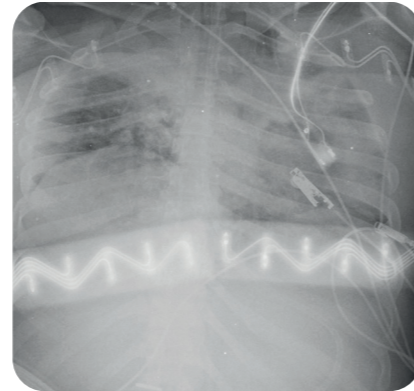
Chest X-ray showing diffuse alveolar infiltrates more intense on the left lung.
